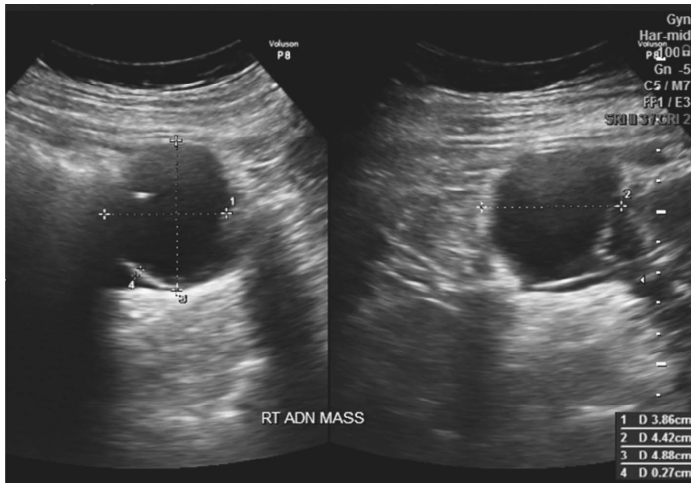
Transabdominal ultrasound of the right adnexal mass on anteroposterior (left) and transverse (right) views.
